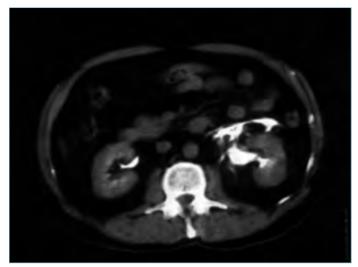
On spiral computed tomography, pararenal extravasation of contrast material in the left
